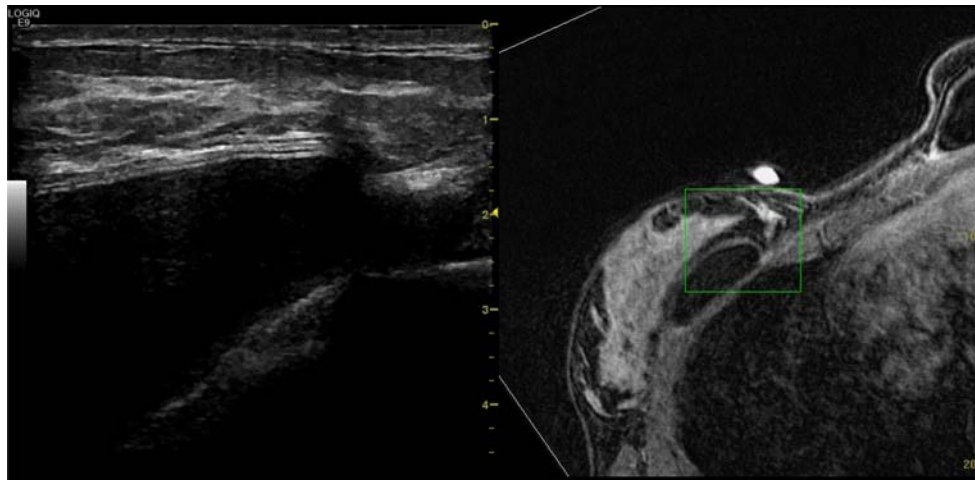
US scan (left side) with the corresponding multiplanar reconstructed MR image (right side) are shown at the same level in Figure 1. The green box represents US scanned area on MR image. Below the capsule at the confluence of internal quadrants—the round high signal intensity over the skin—a suspicious 1.4 cm enhancing MR lesion is depicted, BI-RADS 4. Medially to the lesion the subglandular implant shell is visible as well. On US image, is difficult to recognize any lesion near implant shell. At pathology, obtained with US guided biopsy with VNav, a sclerosing adenosis lesion was demonstrated.
